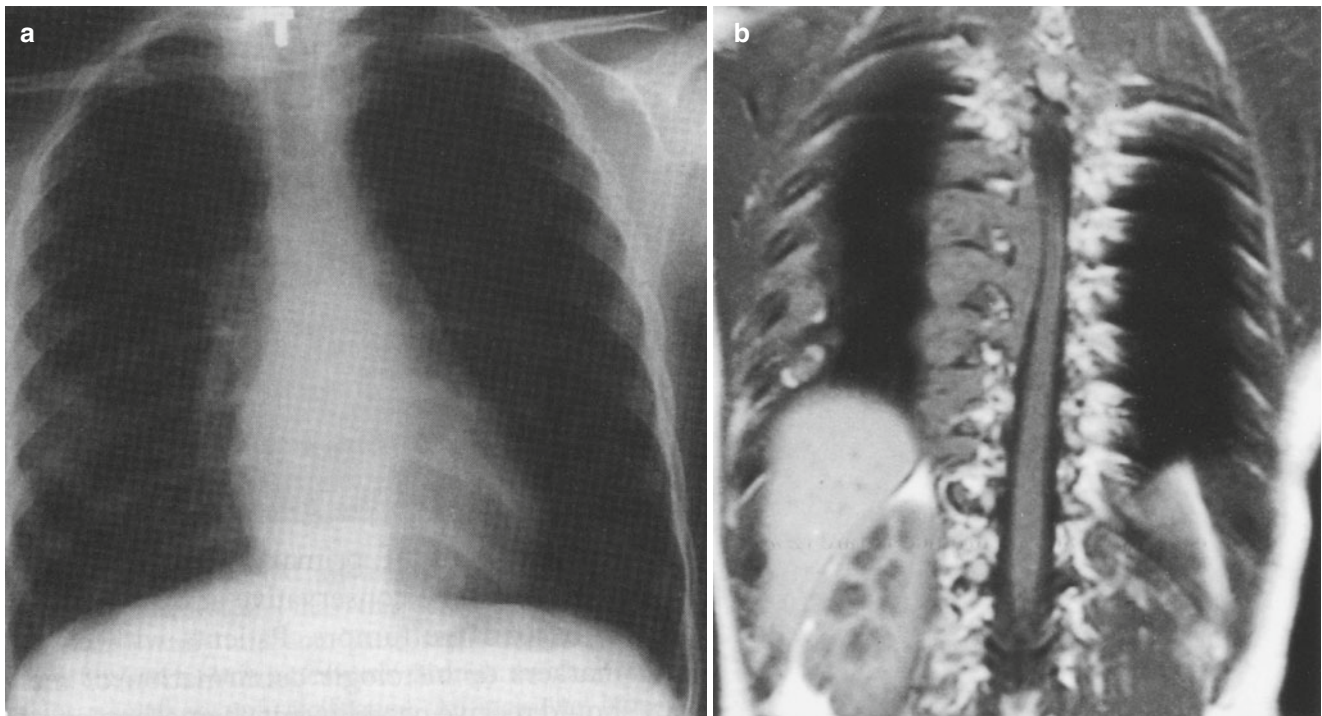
(a) Chest radiograph of a 5 year old girl referred for back pain, which demonstrated a minimal right paraspinal mass, but on the MRI scan (b) a dramatic extension of the tumor was demonstrated
